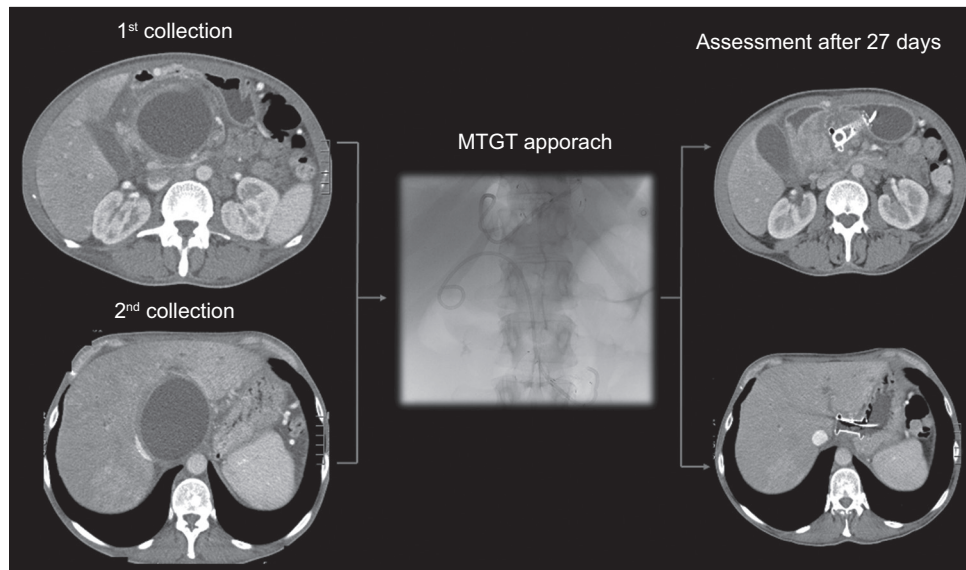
Representative pancreatic pseudocyst case (different patient from Figure 2). Baseline CT demonstrated two pseudocysts measuring $91 \times 70 \times 70$ mm and $78 \times 68 \times 98$ mm. Drainage was indicated because of compression of the portal vein. An EUS-guided cystogastrostomy was performed with creation of two anastomoses, each stented with a LAMS, with a DPS placed through both tracts. Follow-up CT performed 27 days later showed regression of both collections
